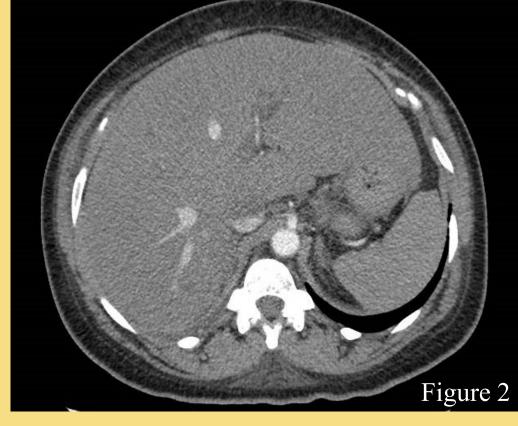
Ultrasound of the abdomen showing hepatomegaly of 19.9 cm in transverse diameter. Figure 2. Contrast CT of the abdomen and pelvis showing marked hepatomegaly
